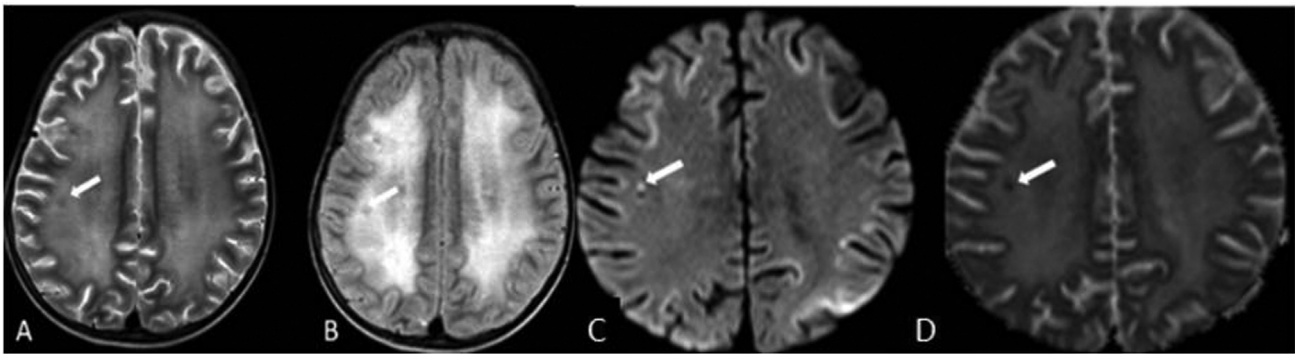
Case 1: Diffuse increased signal intensity is seen in periventricular white matter of bilateral cerebral hemispheres on (A) axial T2-weighted (T2W) and (B) axial fluid-attenuated inversion recovery (FLAIR) imaging. (C) Axial diffusion-weighted imaging and (D) axial apparent diffusion coefficient (ADC) show restricted diffusion with low ADC values in subcortical U fibers of bilateral frontal, parietal, and occipital cortices with corresponding increased signal intensity on FLAIR imaging. White arrow shows T2W and FLAIR hypointense parenchymal lesion showing restricted diffusion with low ADC values in right centrum semiovale.
